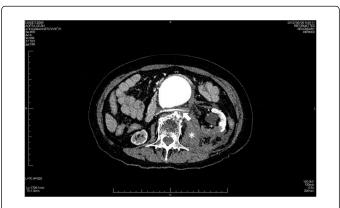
Preoperative contrast-enhanced CT image, showing triple left renal arteries (arrows)
